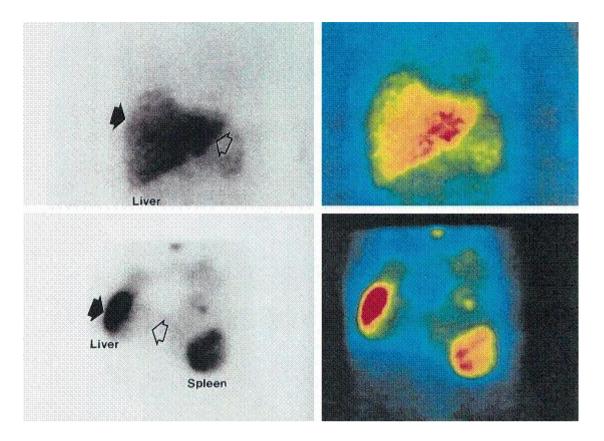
Qualitative difference in the pattern of uptake with [123I]MIBG (upper part of figure), and Octreoscan (lower part of figure) scintigraphy in the same patient with hepatic metastases from an ileal carcinoid.
